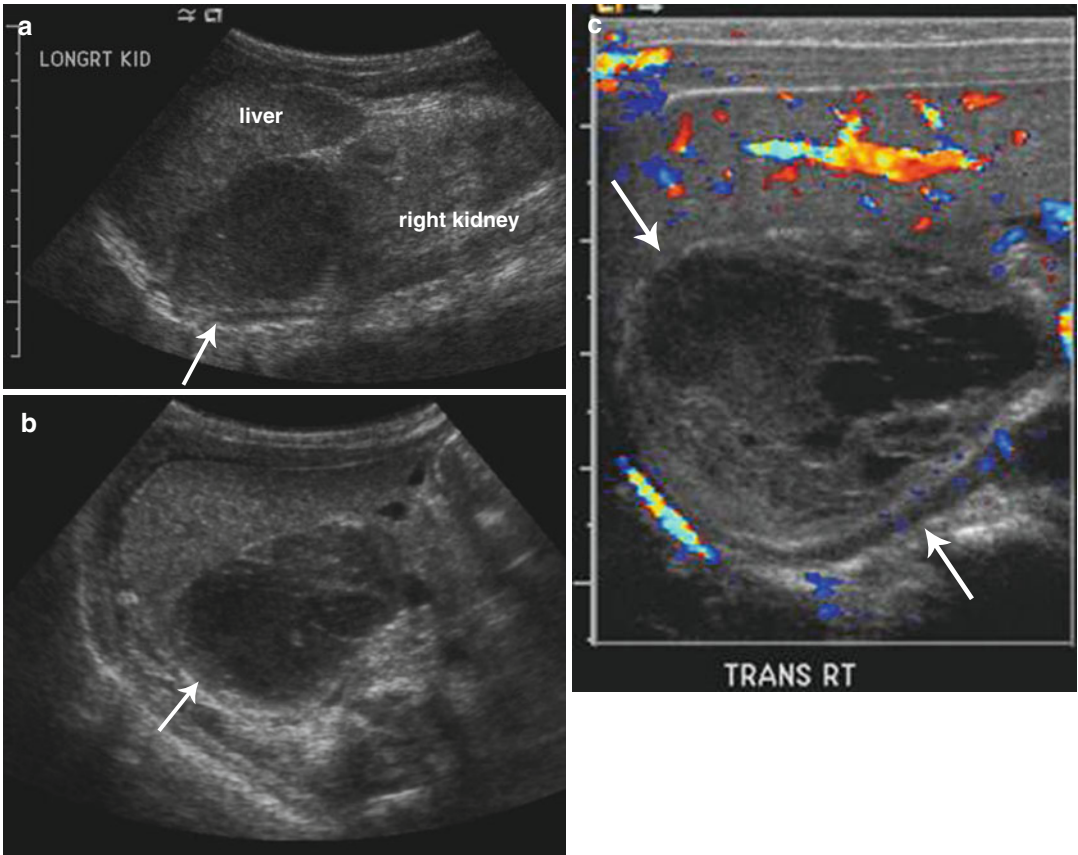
Adrenal hemorrhage. Longitudinal (a) and transverse (b) ultrasound images in a 2-week-old boy with right adrenal hemorrhage reveal a rounded heterogeneously
